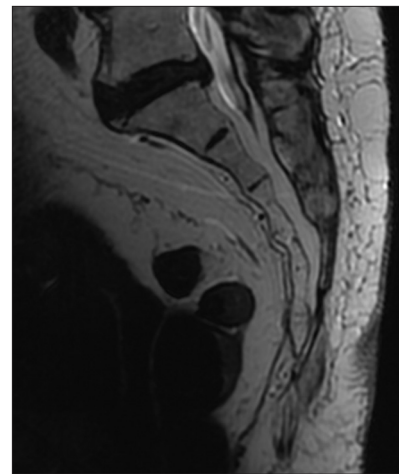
Magnetic resonance imaging T2 sequence shows hypointense around sacrococcygeal area, suggestive of inflammation and hypermobility
